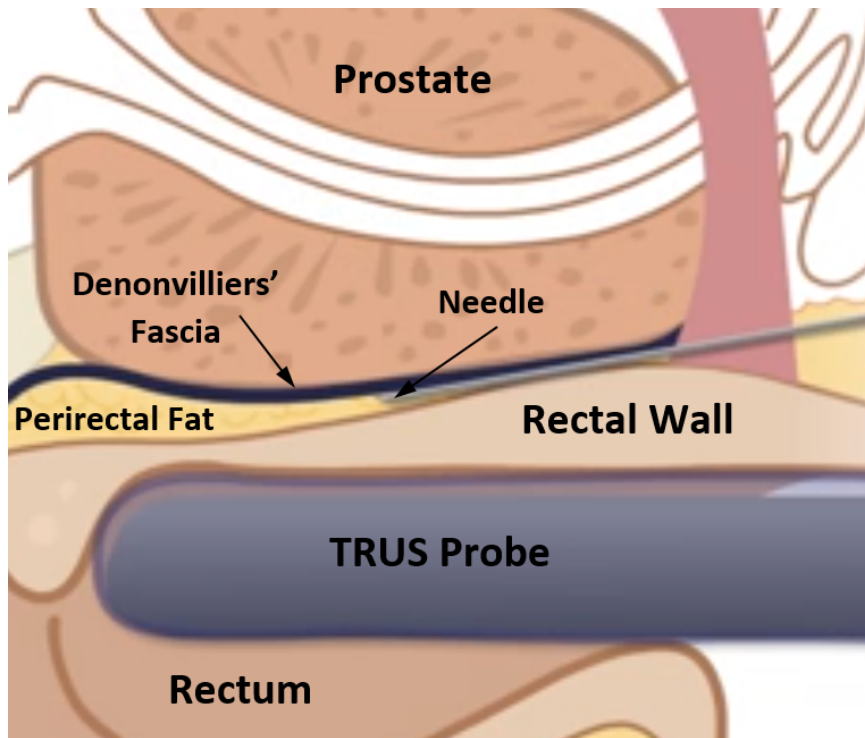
Clinical set-up for SOH implant with the use of a transrectal ultrasound probe for image guidance of the 18G needle into the perirectal fat. Image adapted from SpaceOAR© system instructions for use.⁵²
